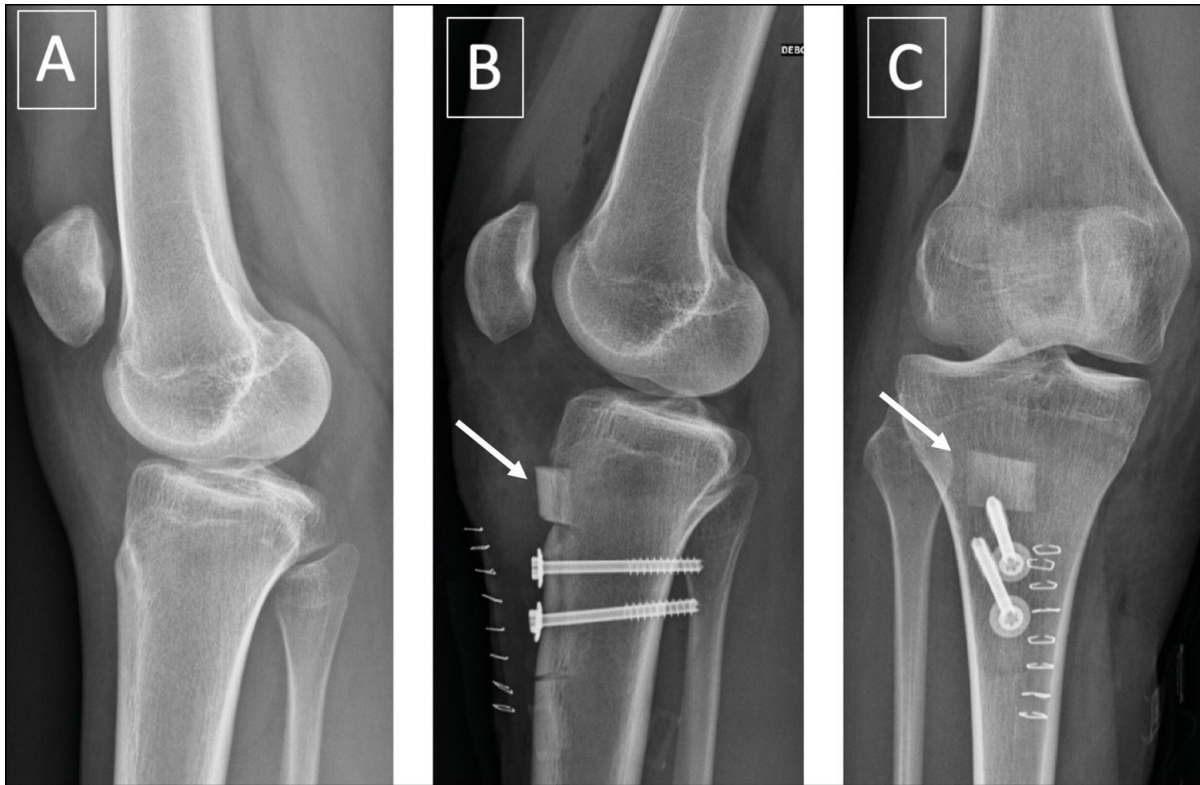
Preoperative lateral x-ray showing the patella alta (a); lateral and frontal postoperative views (b,c) with a normal patellar height.
